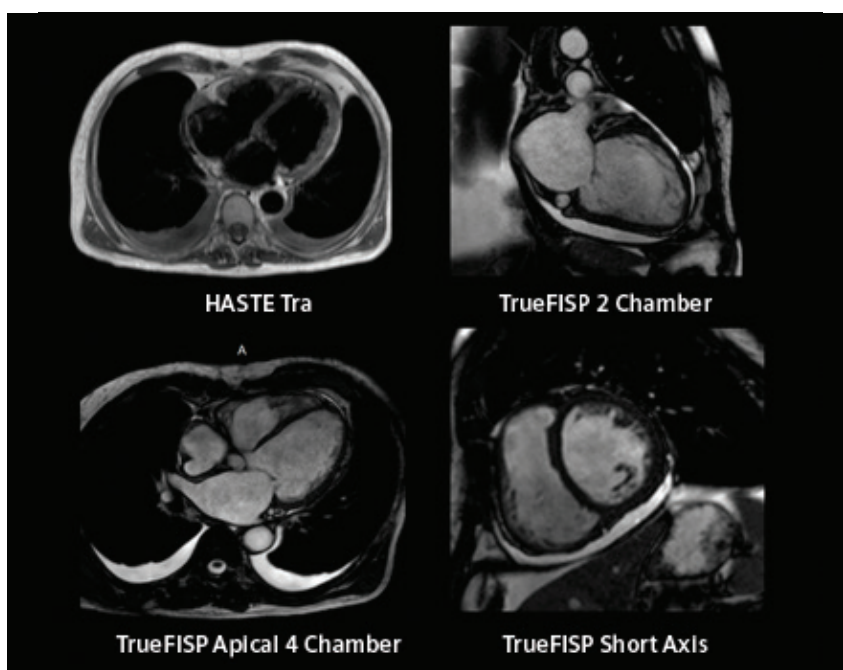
Non-contrast MR images show a dilated LV with thinning of the anterior wall, septum and apex.
